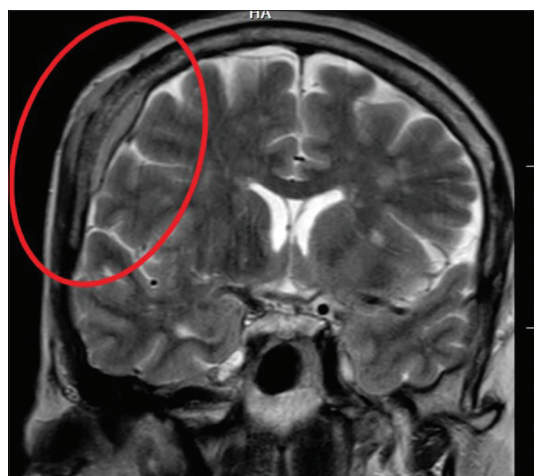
The cranial magnetic resonance imaging of the patient showing a lesion in the right temporoparietal area with bone erosion
